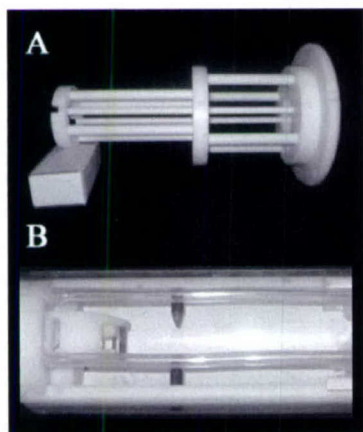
Mounting plane (A) custom designed for 20 cm bore MRI. Stereotaxic device (B) showing ear and teeth bars plus gas anesthetic supply and scavenging lines.
